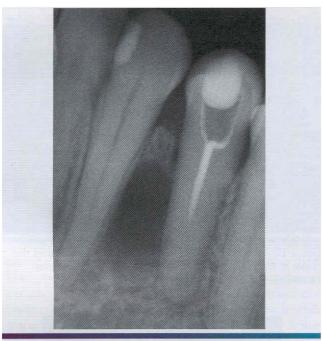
• Odontogenic keratocyst. This cyst cannot be radiographically differentiated from a lateral periodontal cyst. (Courtesy of Dr. Keith Lemmerman.)
